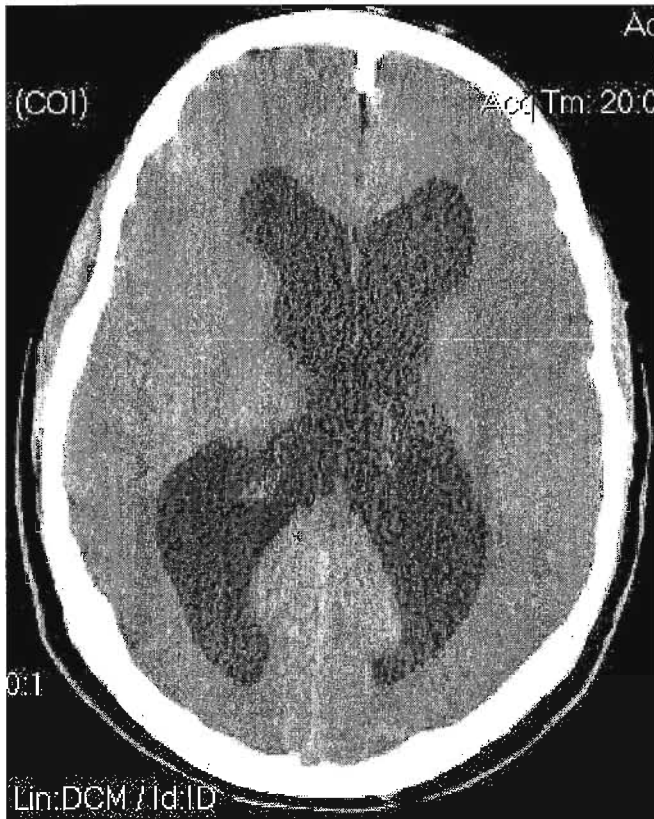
Head CT of 47 year-old gentleman diagnosed with chronic hydrocephalus.*
